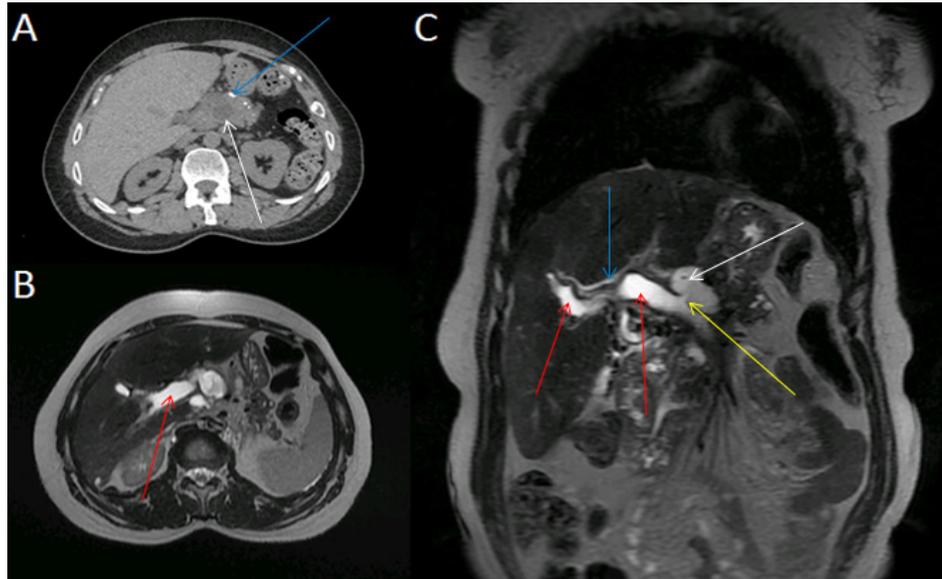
(A), a non-injected abdominal CT scan showing pancreatic cyst (white arrow) and pancreatic calcifications (blue arrow); (B), T2 MRI showing fluid portal thrombosis (red arrow) C, T2 MRI showing a pancreatic false cyst (white arrow), cysto-portal fistula (yellow arrow), and fluid portal thrombosis (red arrows). To the non-expert eye, liquid portal thrombosis could mimic obstructive bile duct dilatation. However, the intrahepatic bile ducts were normal (blue arrow).
